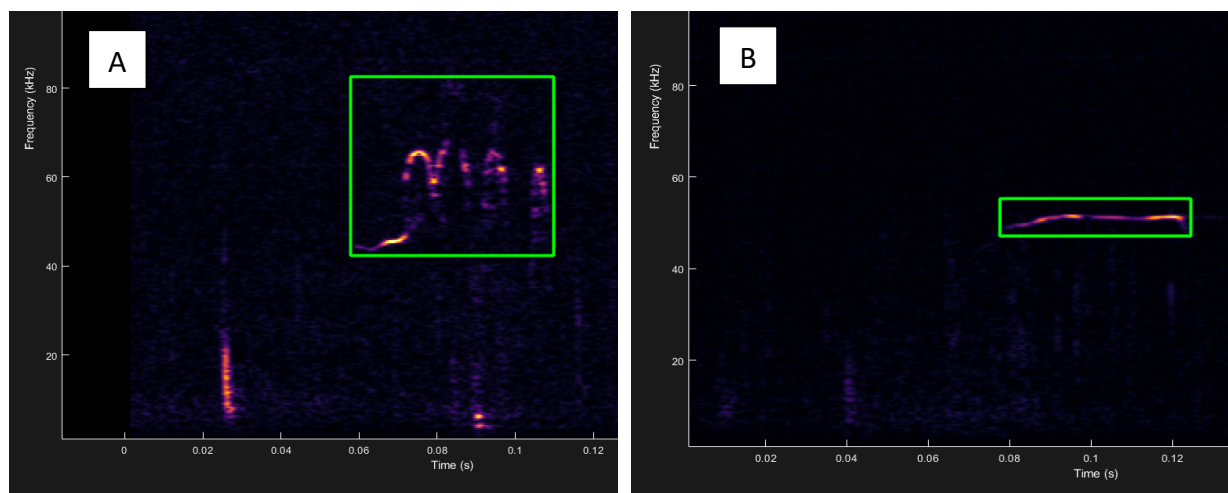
Examples of spectrograms of ultrasonic vocalizations obtained from DeeqSqueak with time in seconds on the x-axis and frequency in kHz on the y-axis. A: Green box surrounding a complex call; note the frequency modulation between 40 and 65kHz. B: Green box surrounding a simple call; notice the flatness of contour with limited change in frequency around 50kHz.
